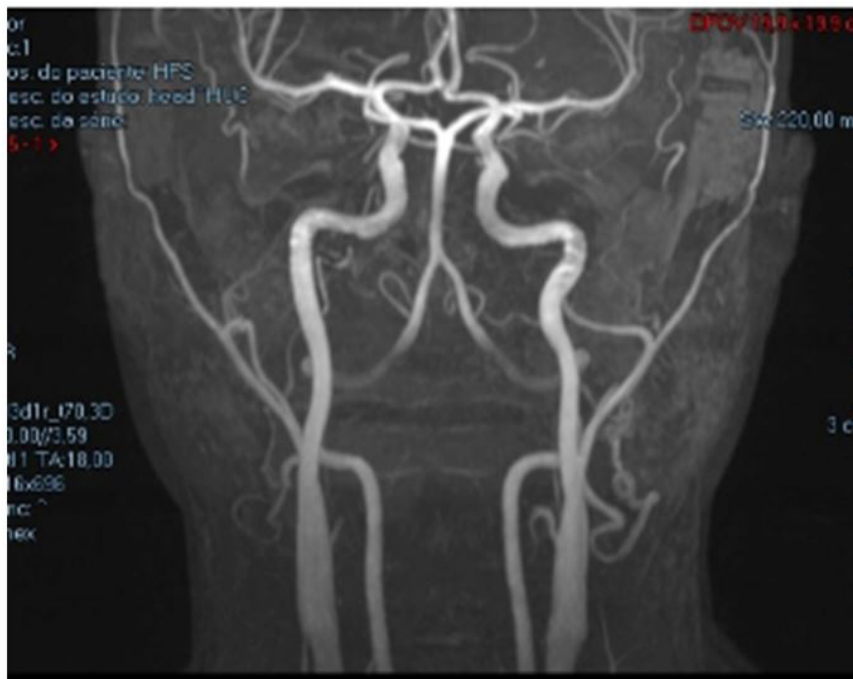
Angiography by MRI. Vascular conglomerate in the left hemiface
